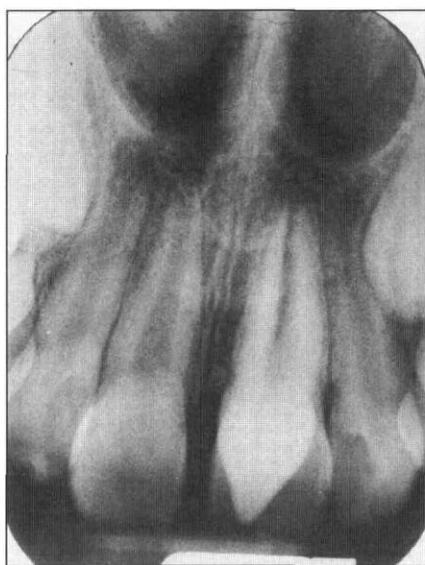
Periapical radiograph of maxillary left permanent central incisor and labial supernumerary tooth.
